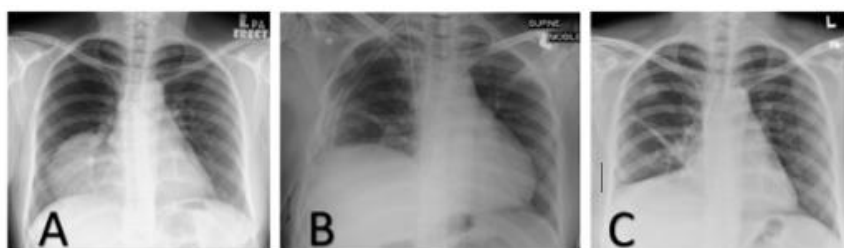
A: Chest x-ray upon presentation, B: Immediate post-operation, C: Reassessment
